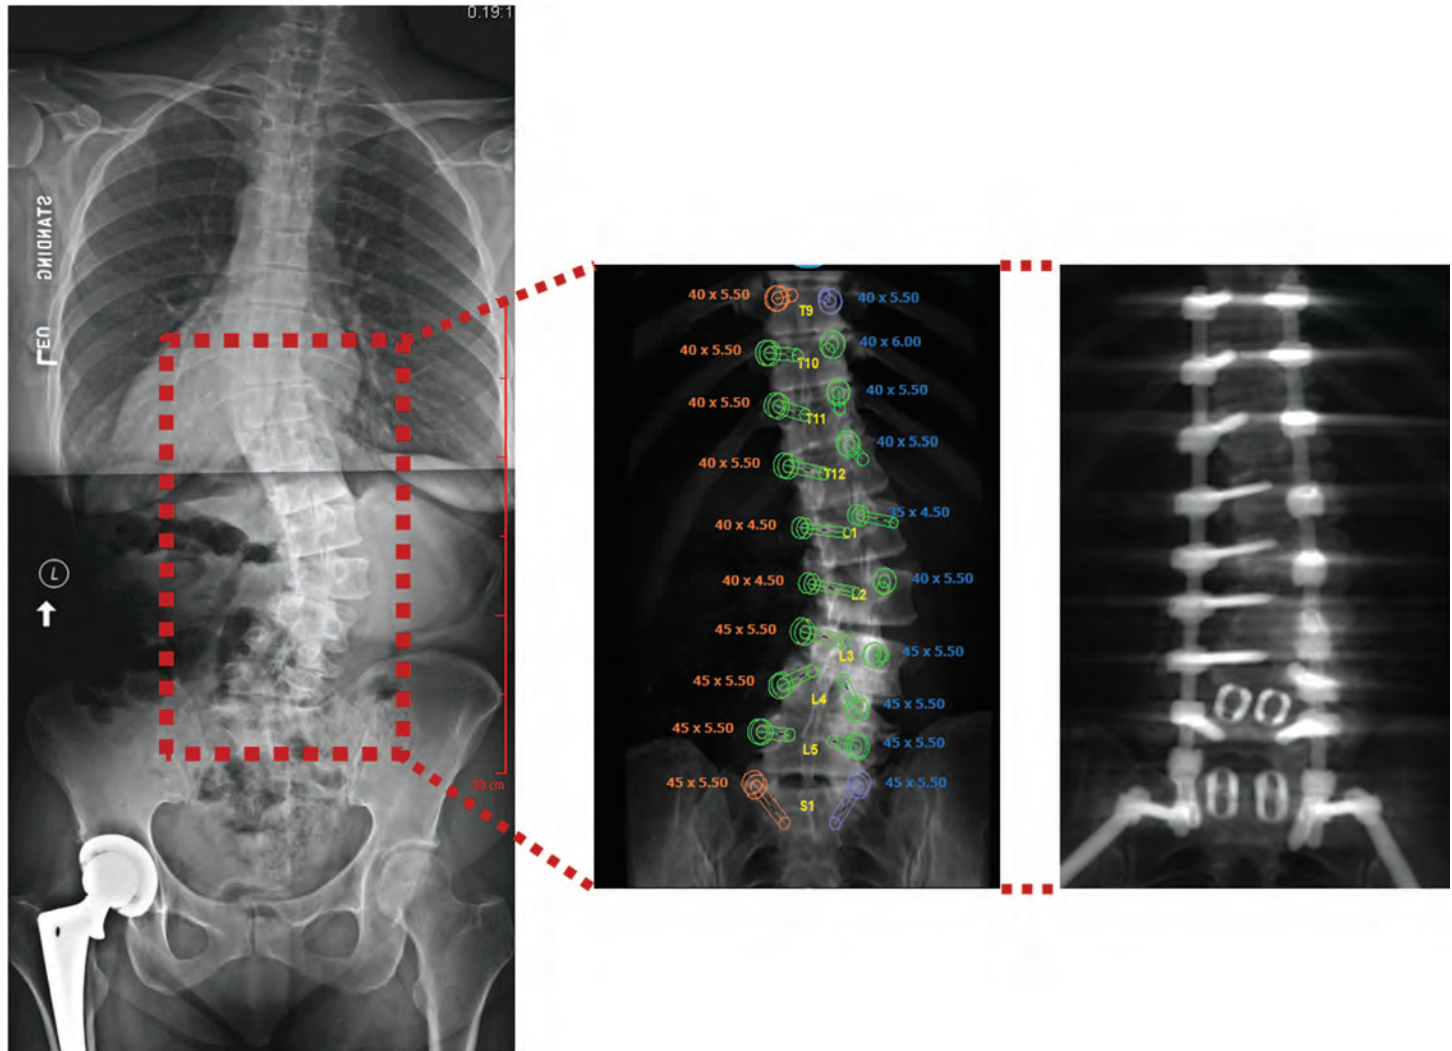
Left: x-ray of patient with thoracolumbar scoliosis. Center: pre-operative blueprint showing the location where screws will be placed during scoliosis correction surgery. Right: final location of the implants after surgical correction.
